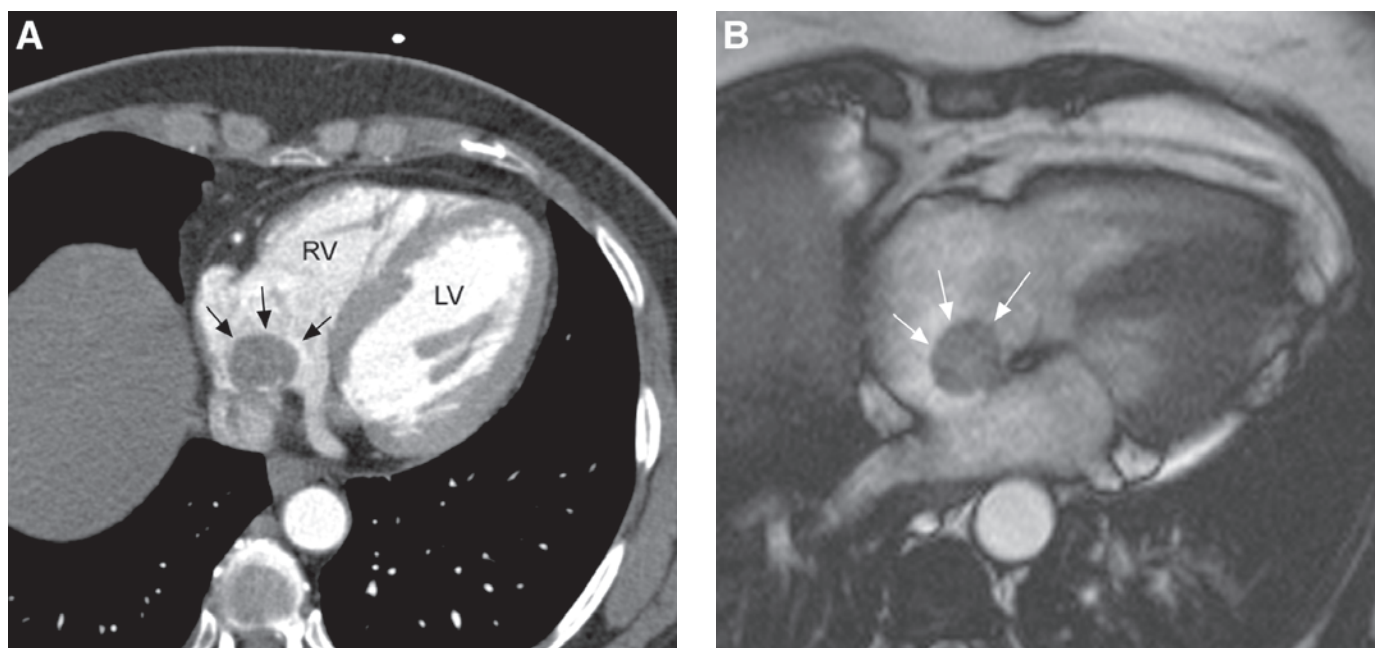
(A) Round-shaped myxoma of the right atrium with small calcifications (arrows). RV, right ventricle; LV, left ventricle. (B) Corresponding magnetic resonance imaging in long-axis orientation show the stalk of the myxoma (arrows) attached to the oval fossa.
